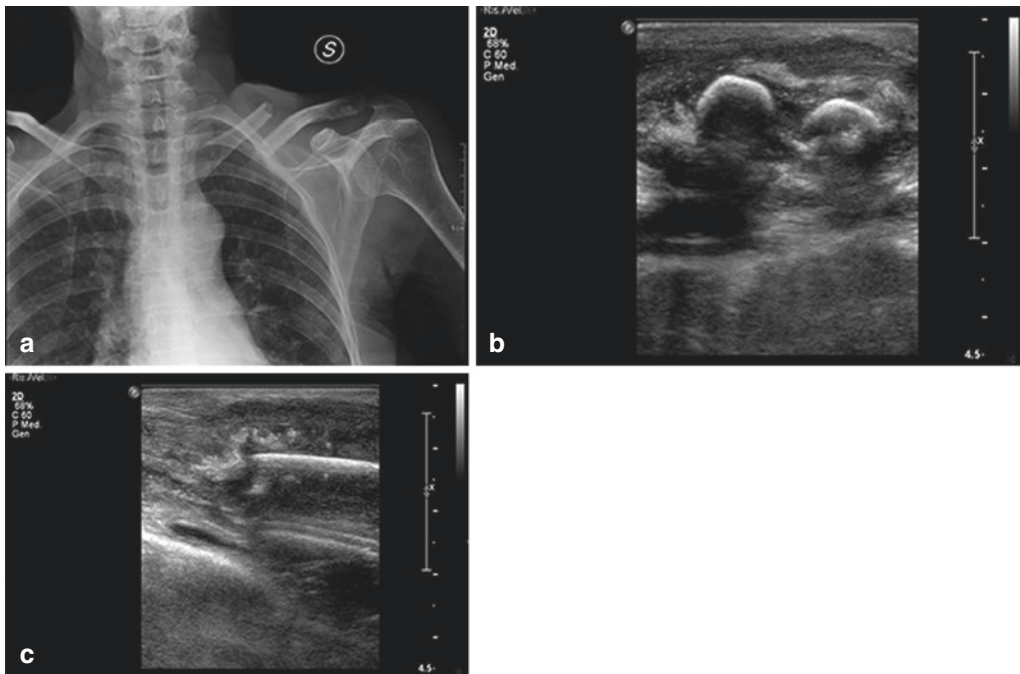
Fracture at the middle third of the left collarbone. X-ray (a) and ultrasound (b, c)
